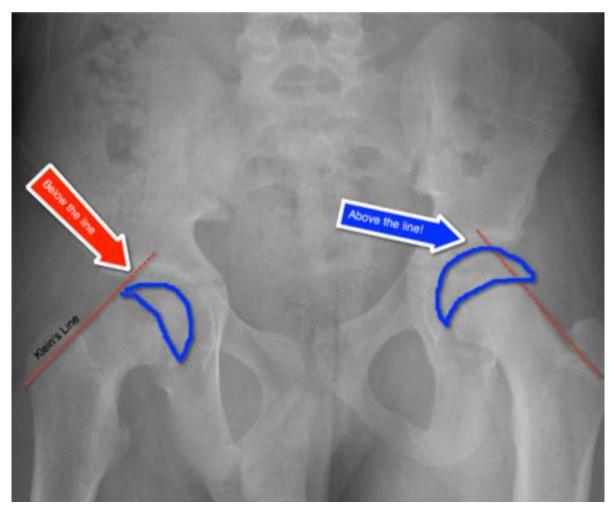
AP pelvis x-ray showing right sided SUFE. Trethowan's sign is demonstrated on the right; Klein's line, drawn along the superior aspect of the femoral neck, does not intersect the superior femoral epiphysis. (Source: Orthobullets)
